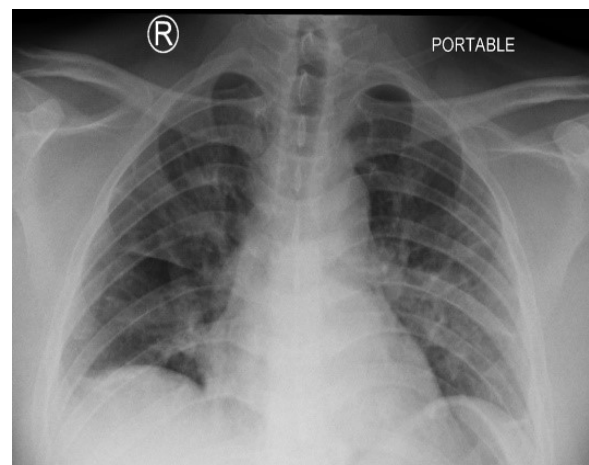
Chest radiograph demonstrating ill defined subsegmental consolidations in both lungs, predominantly in right upper and left mid zone.
